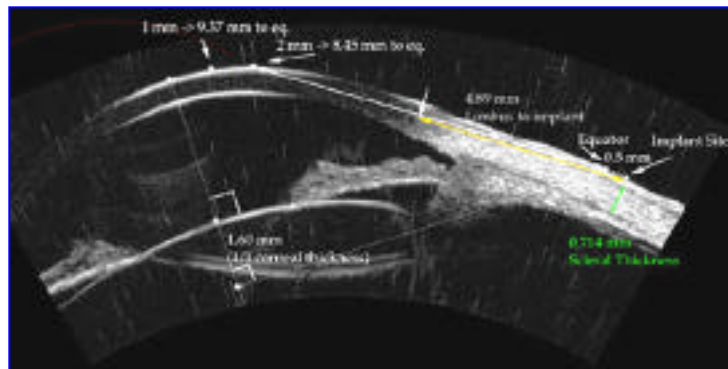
Artemis 2: Software application for determining the exact placement location for scleral expansion band inserts. These must be placed 500-µm behind the point on the sclera intersecting with the line bisecting equator of the lens. Only Artemis can provide this determination thanks to the combined optical and ultrasound B-scan image capture technology
